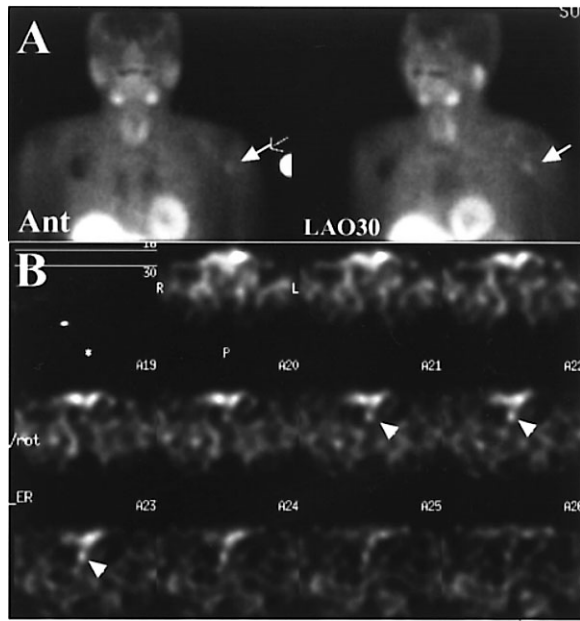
Early-phase planar (A) and SPECT (B) images with Tc-99m-MIBI in a patient (case No. 3) with autograft-dependent hyperparathyroidism. Planar images demonstrate increased uptake in the autograft in the left upper arm medially (arrows). SPECT images shows increased focus in the left upper mediastinal region adjacent to the trachea (arrowheads). This was considered as a false-positive because clinical symptoms and PTH improved promptly after the removal of the enlarged autograft and no recurrence was observed.
